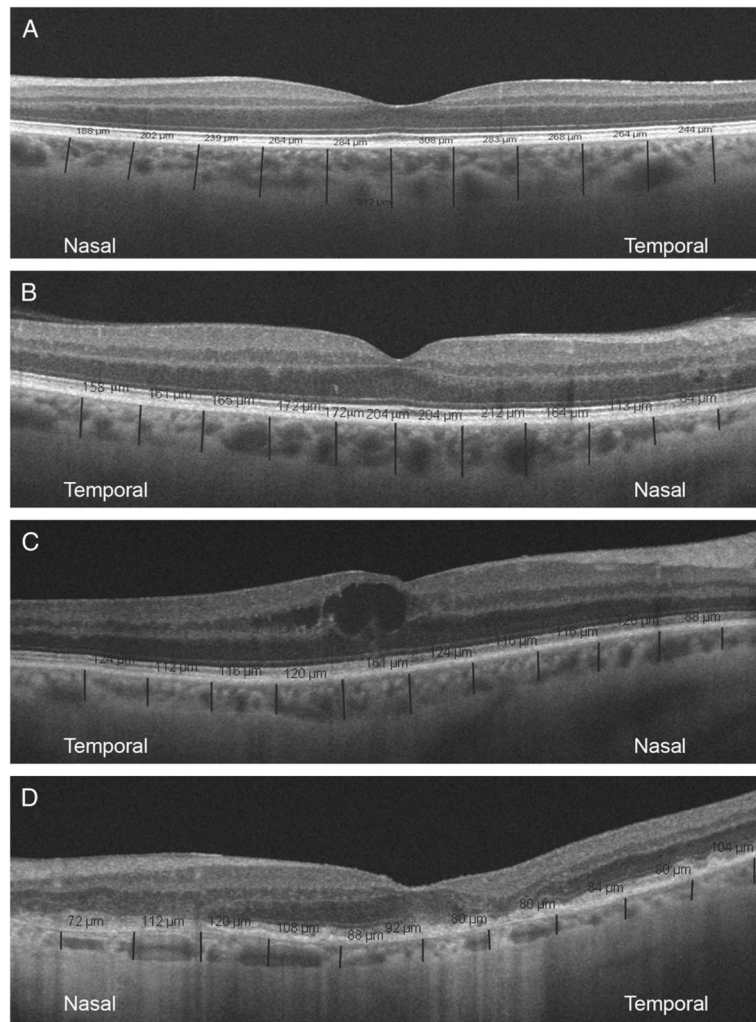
Representative scans with CT measurements on Cirrus HD-OCT high-definition 1-line raster scans. Perpendicular lines were drawn from posterior edge of RPE to choroid/sclera junction using Cirrus HD-OCT software. Choroidal thickness was measured in the fovea and at 500- μm intervals nasal and temporal to the fovea with the measurements expressed as micrometers (red lines). Note that the choroid is thickest at center, thinner temporally, and thinnest nasally. A. Representative scan from a normal subject; (B) representative scan from a patient with mild non-proliferative diabetic retinopathy; (C) representative scan from a patient with moderate nonproliferative diabetic retinopathy and diabetic macular edema; (D) representative scan from a patient with treated proliferative diabetic retinopathy, note that there is a disruption in the photoreceptor inner/outer segment junction probably because of the retinal ischemia.
